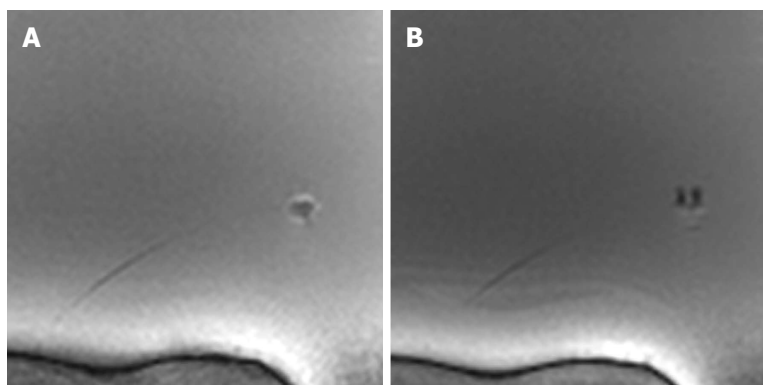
Real-time magnetic resonance imaging image frames with opened (A) and moving (B) tip.
